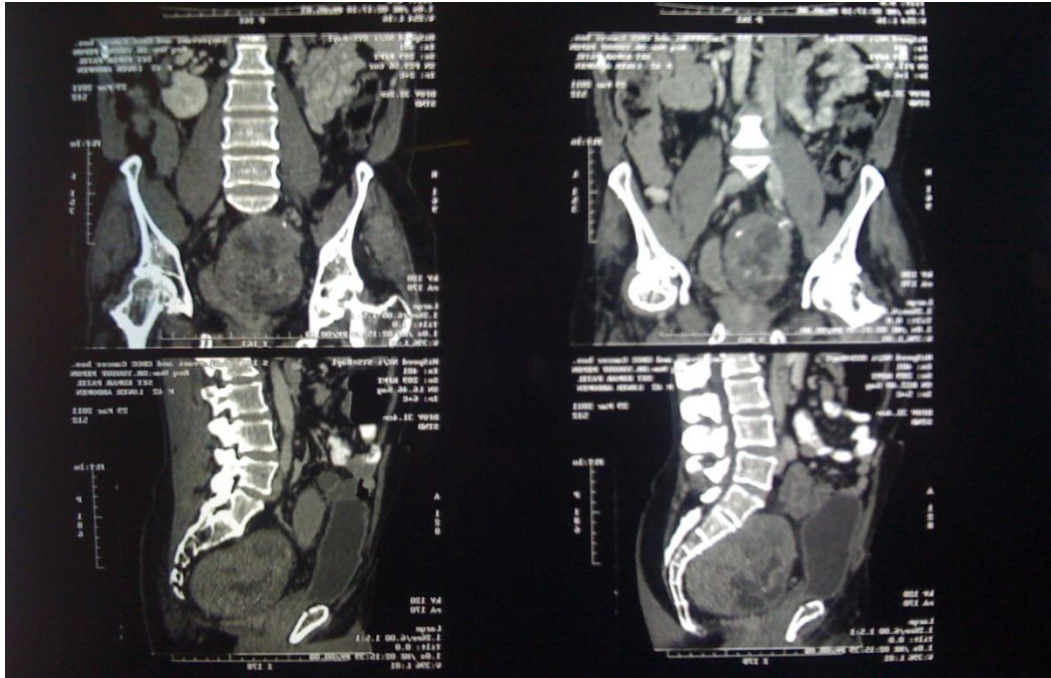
CT showing sagittal view of lower abdomen
